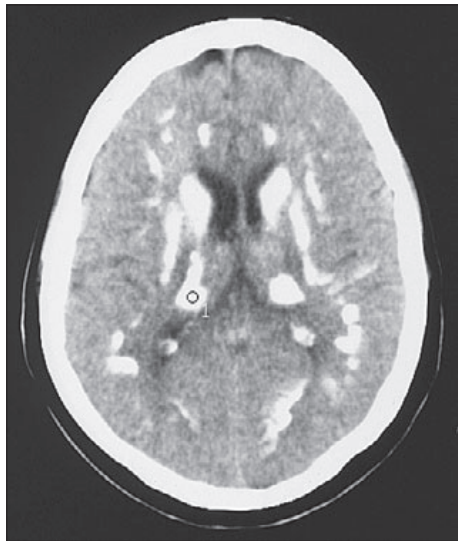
CT of the brain – diffusely situated numerous calcificates (periventricular, subcortical, centrum semiovale).
